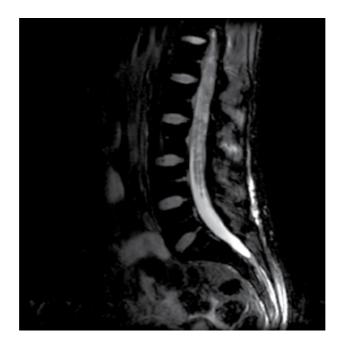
MRI of the lumbosacral spine demonstrating diffuse radicular nodularity
